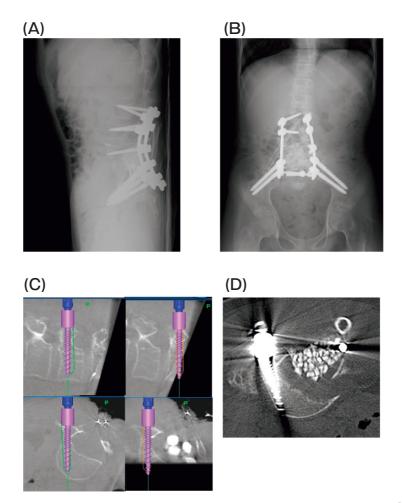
(A,B) X-ray images after posterior fixation from L3 to the pelvis using bilateral fibular bone grafts; (C) intraoperative navigation images (left column, L4 vertebra; right column, L5 vertebra); (D) CT image of the pedicle screw inserted into the L5 vertebra using O-arm navigation.
